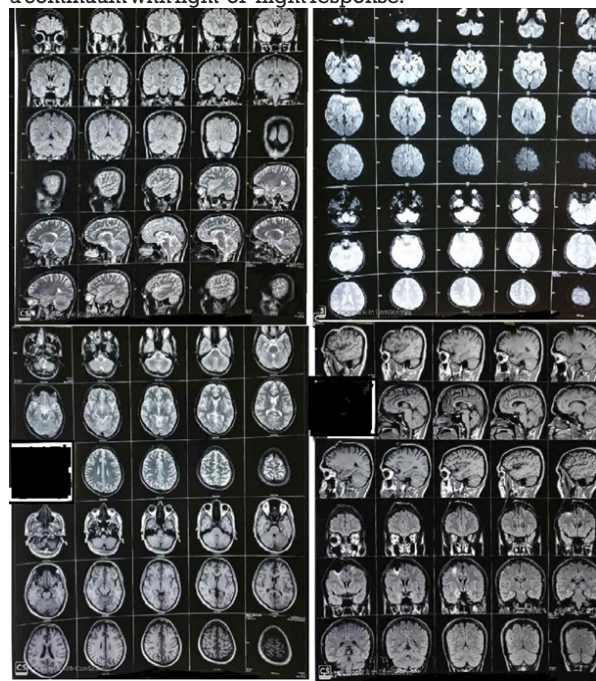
Postoperative MRI Brain Imaging Showing Linear T2W / FLAIR Hyperintense Tracts In The Frontal Lobe Extending To Amygdala Through Corpus Striatum Bilaterally.
